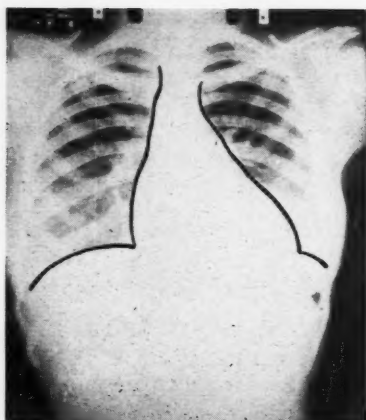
Erect posteroanterior x-ray view of the chest. Cardiac silhouette outlined.
